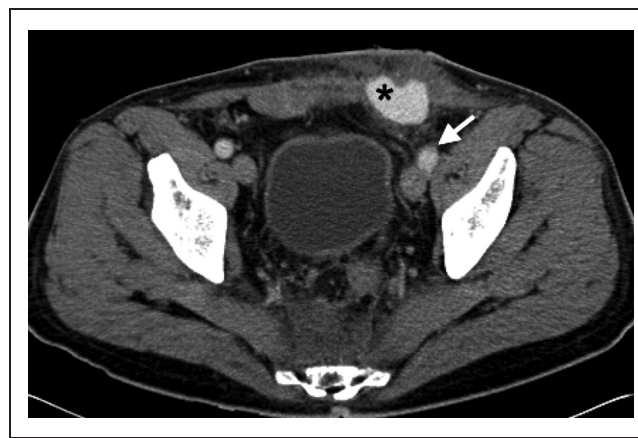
Axial computed tomography at the level of the Pfannenstiel incision. The pseudoaneurysm (asterisk) is evident in the left rectus sheath. Note how the enhancement matches that of the external iliac artery (arrow).
